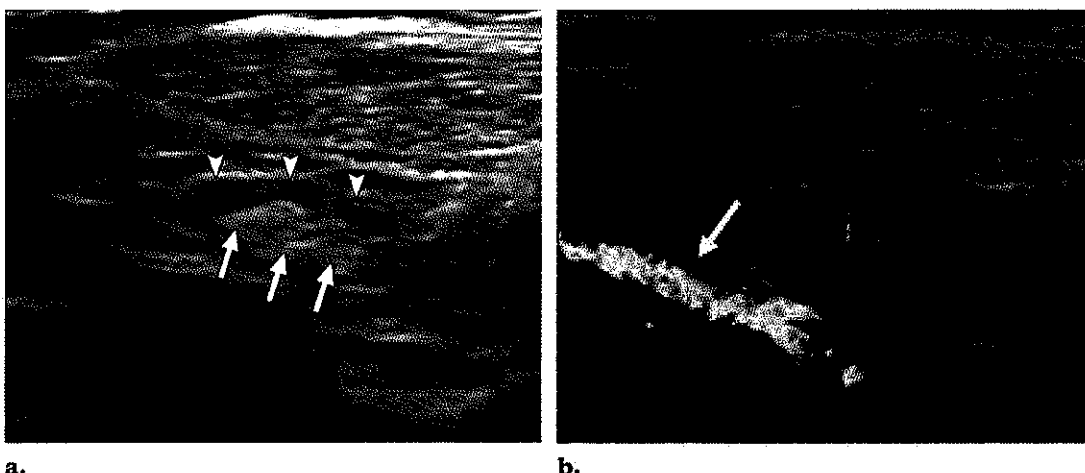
(a) US image shows a normal lymph node with a thin cortex (arrowheads) and a fatty hilum (arrows) (cf Fig 1a). (b) Color Doppler US image demonstrates an adjacent vein (arrow). Lymph nodes are often located near vessels and nerves.
